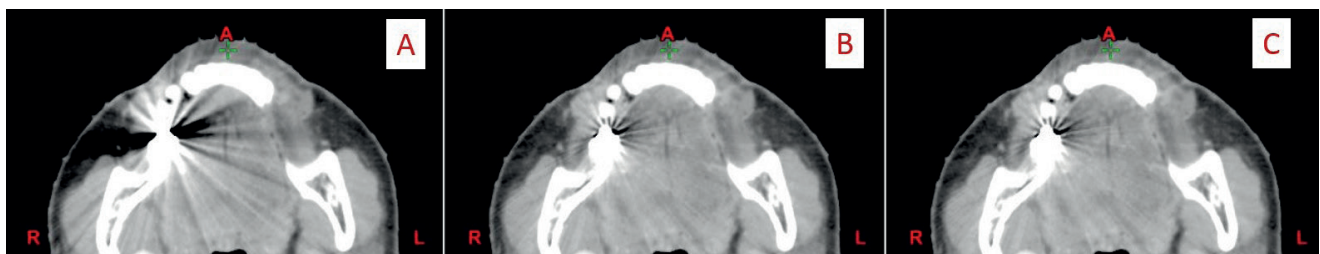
Patient computed tomographic images with metal artifacts reconstructed by 3 algorithms. A: FBP, B: OMAR, C: new method.
